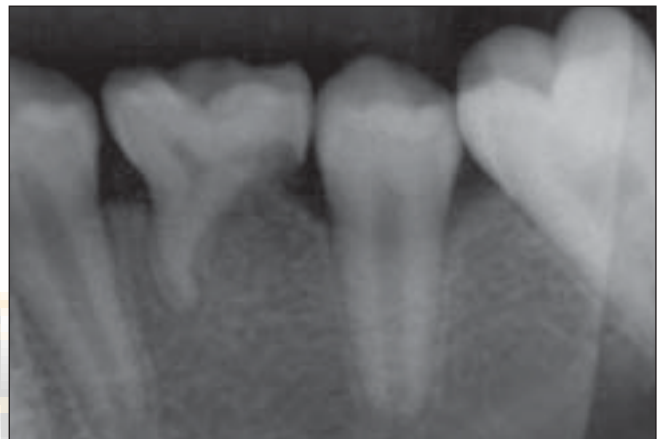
Radiograph showing over retained 75 along with congenitally missing 36
